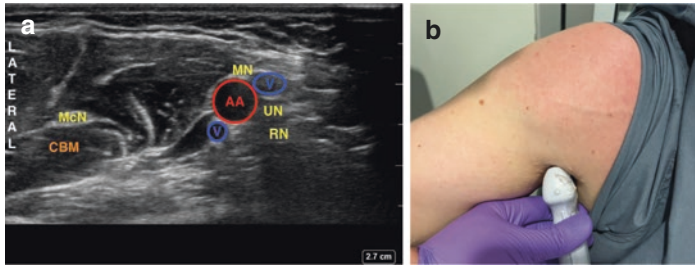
(a) Ultrasound image of axillary approach to brachial plexus nerve block. AA axillary artery, V vein, MN median nerve, UN ulnar nerve, RN radial nerve, McN musculocutaneous nerve, CBM coracobrachialis muscle. (b) Ultrasound probe placement to obtain axillary view
